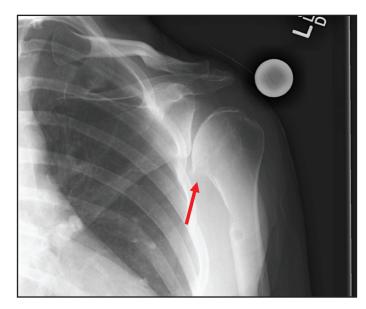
Anterior to posterior radiographic view of the left shoulder demonstrating a dramatic decrease in size of inferior humeral head osteophyte status post humeral osteoplasty.
